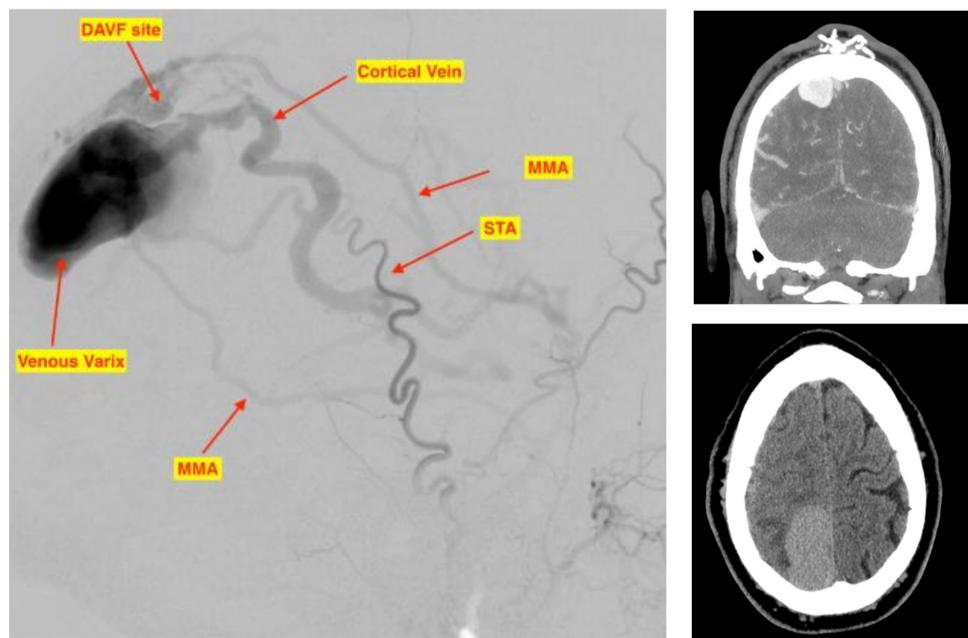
Angiogram shows dAVF and associated cortical vein and venous varix. CT without contrasts demonstrates a large paramedian venous structure with superficial cerebral draining veins corresponding to angiogram findings.
